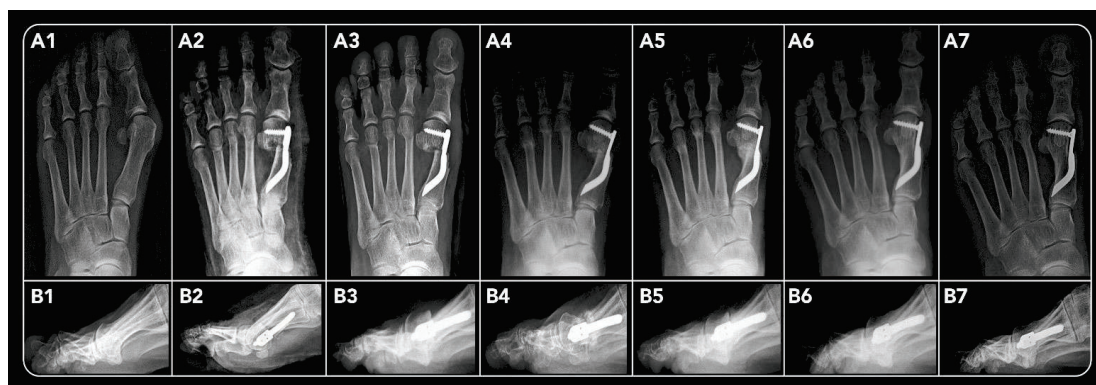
(Case 2): a 58-year-old female patient having undergone DMMO of the M2, M3, and M4 in association with Endolog technique for HV correction of her left foot, radiographic images of anteroposterior (A) and lateral views (B): at preoperative period (1), immediate postoperative period (2), 1-month follow-up (3), 3-month follow-up (4), 6-month follow-up (5), 12-month follow-up (6), and 48 months after surgery (7), showing bone callus consolidation and its remodeling, maintaining the shortening and elevation of the head of the MBs treated.
